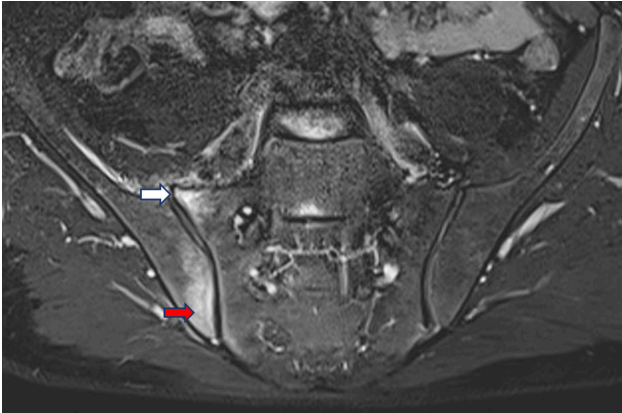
Sacroiliac joint magnetic resonance image from a 38-year-old man with Brucellar sacroiliitis. Coronal T2-weighted fatsat image shows significant signal increase inferior to the iliac bone (red arrow) and superior to the sacral bone (white arrow) in the right sacroiliac joint.
